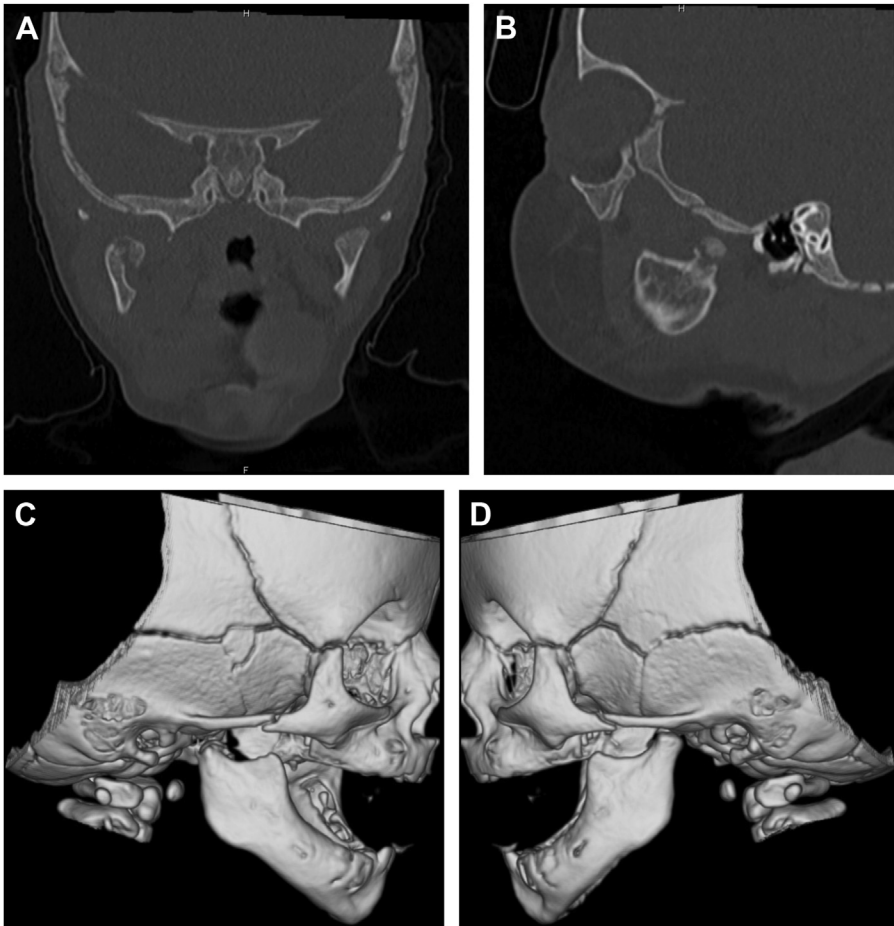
Case of a condylar fracture in an infant that was managed with observation. CT of the face demonstrating medial displacement of the right condylar head on (A) coronal and (B) sagittal views. (C, D) Three-dimensional reconstruction of the CT scan demonstrating the loss of vertical mandibular height on the right compared with the left.
